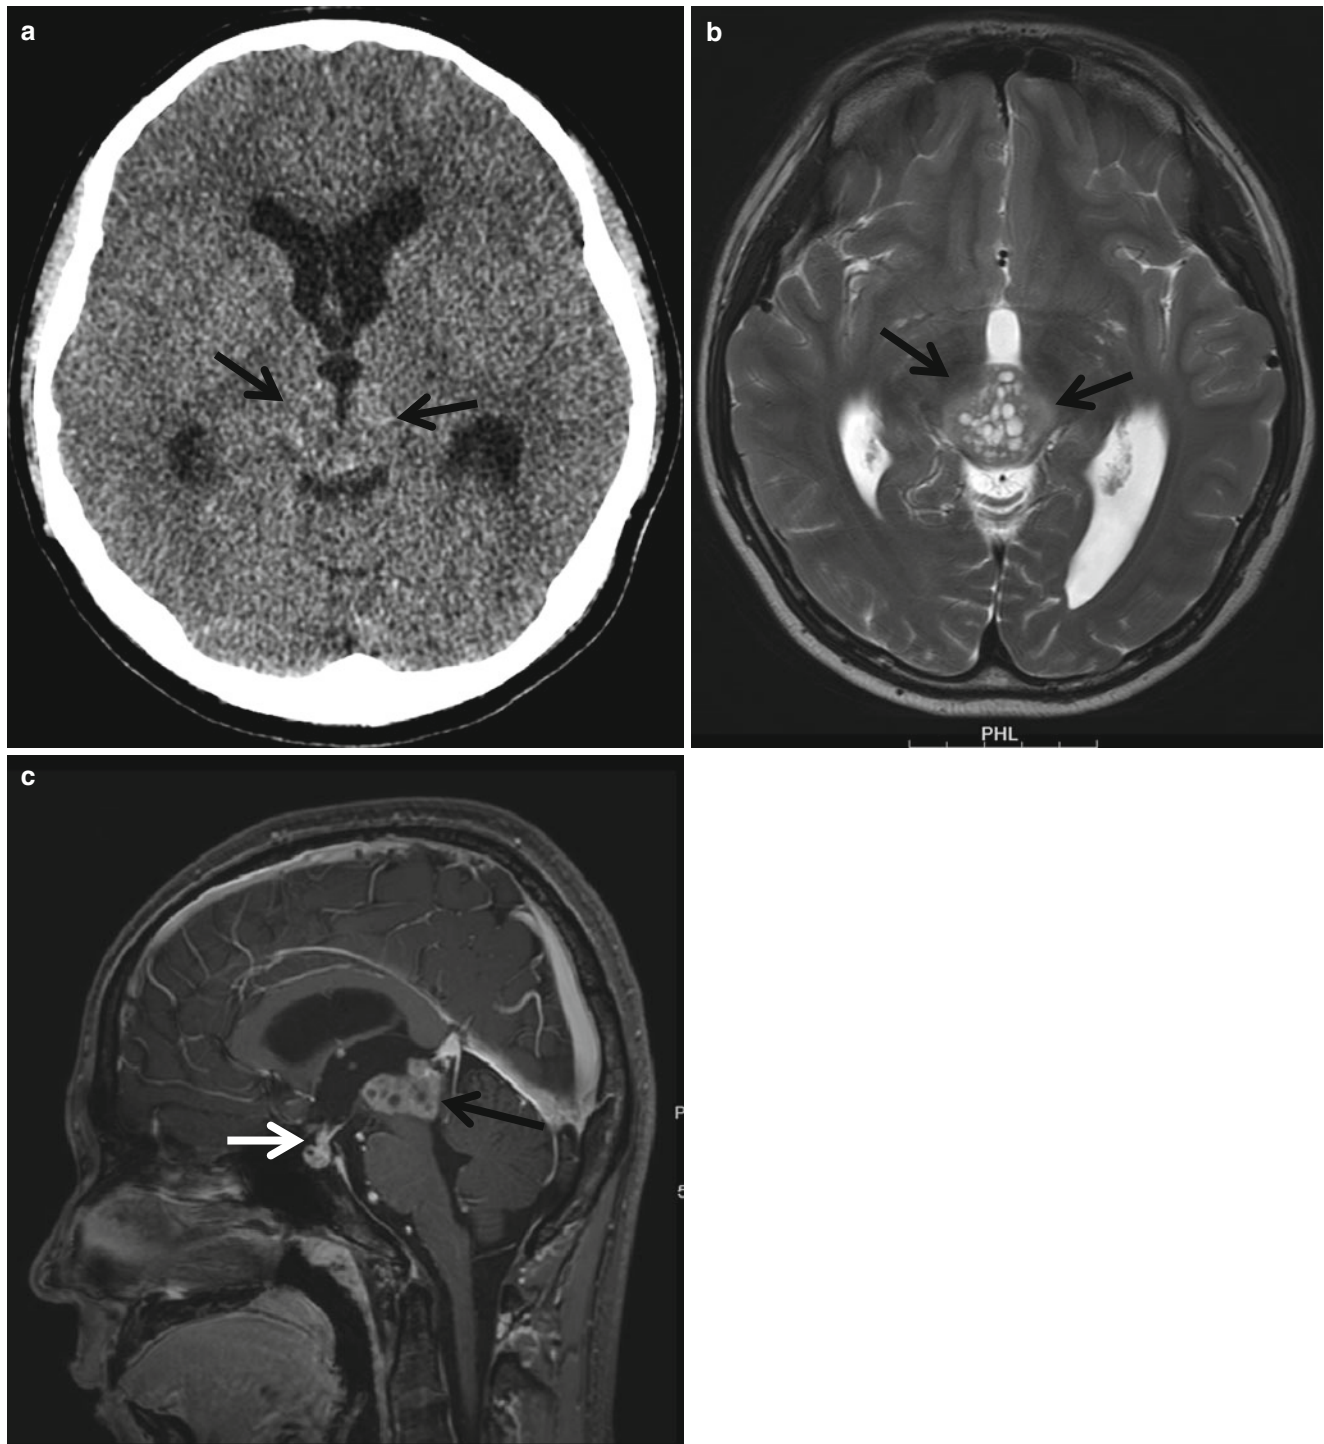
Pineal and suprasellar germinoma in a 16-year-old boy. (a) CT scan shows isodense mass (*arrows*) at the pineal area. (b) T2-weighted image shows isointensity pineal mass (*arrow*)
